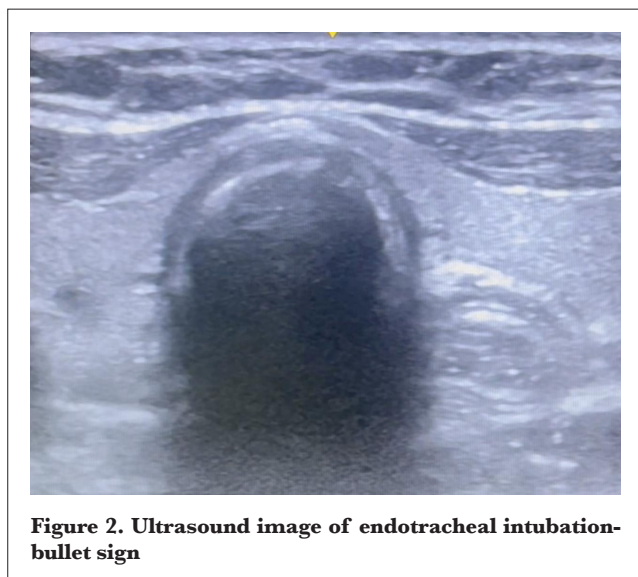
Ultrasound image of endotracheal intubation-bullet sign
